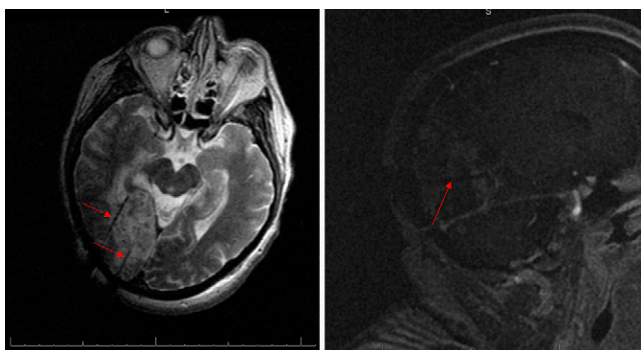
Intraoperative MRI-guided laser probe placement confirming location of probes within tumor bed and avoiding cesium seeds. Left: Axial view. Right: Sagittal view. *Red arrows* point to laser probes.
